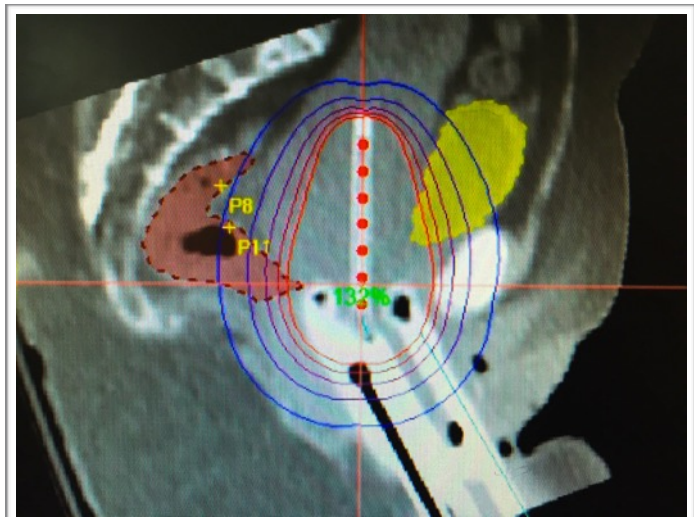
Coronal section CT image showing the central applicator and ring with surrounding dose distribution in a pear shape. Point A is marked in green. The red markers are the dwell positions of the Iridium<sup>192</sup> source.
